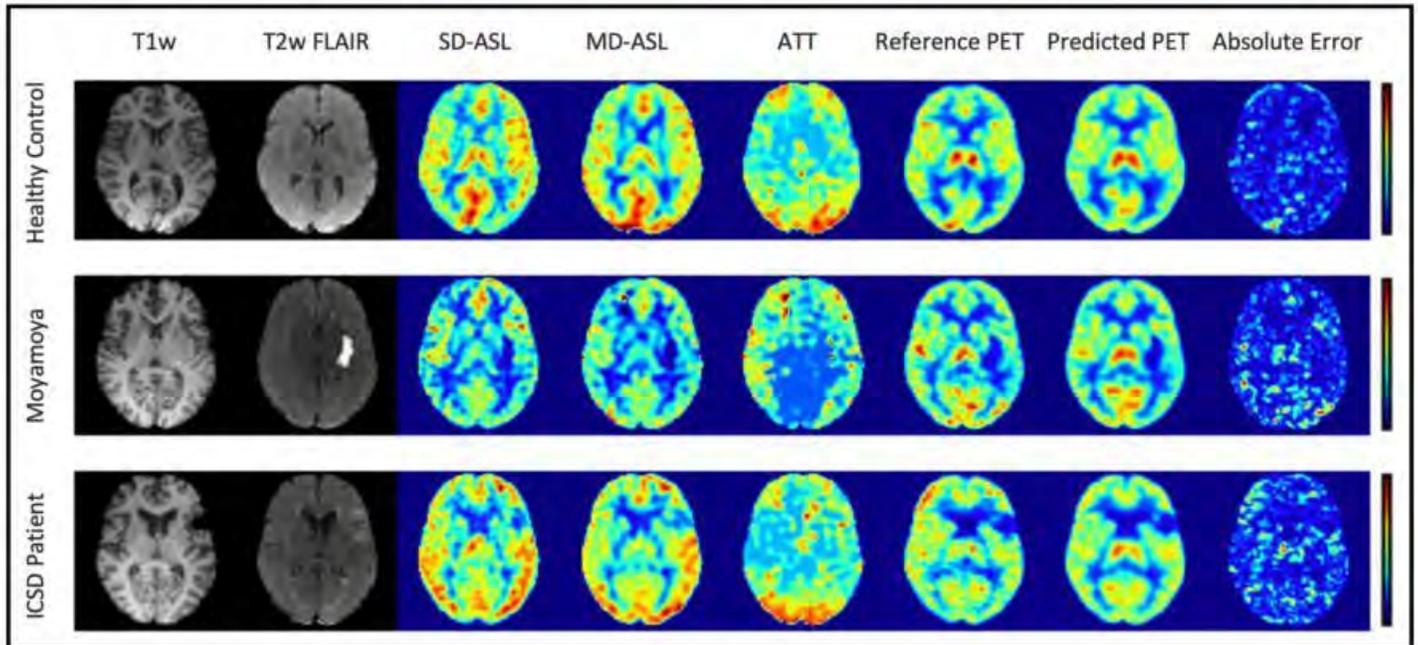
Examples of multi-contrast MRI sequences, reference PET CBF, corresponding synthetic PET CBF, and absolute error maps.
